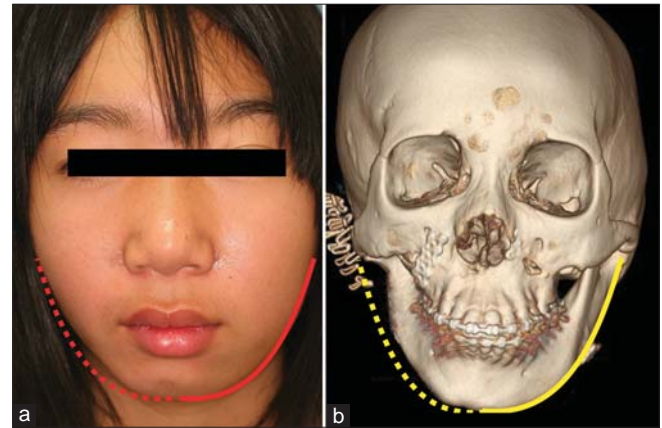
The 12-year-old girl with type IIb right-sided hemifacial microsomia, (a) Frontal view. The dashed red line is a reflected image of solid red line of unaffected side and indicates asymmetry of mandibular contour, (b) Computed tomography (CT) image. The dashed yellow line is a reflected image of solid yellow line of unaffected side
